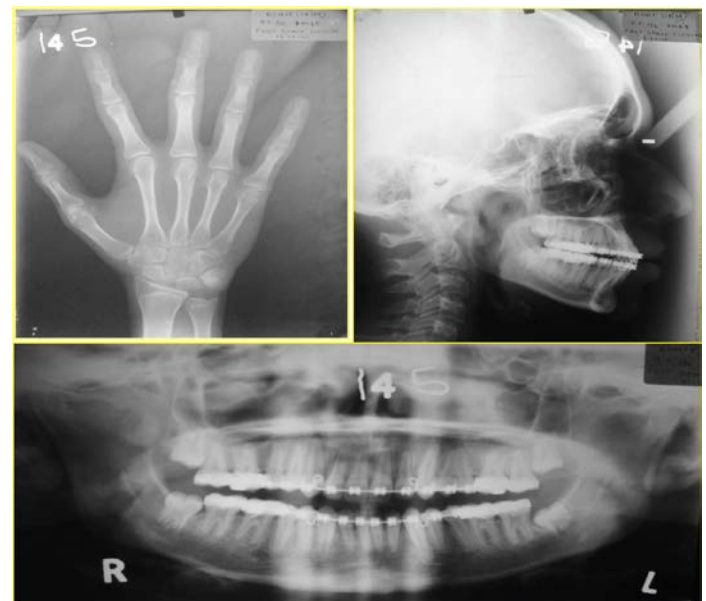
Postfunctional radiographs
